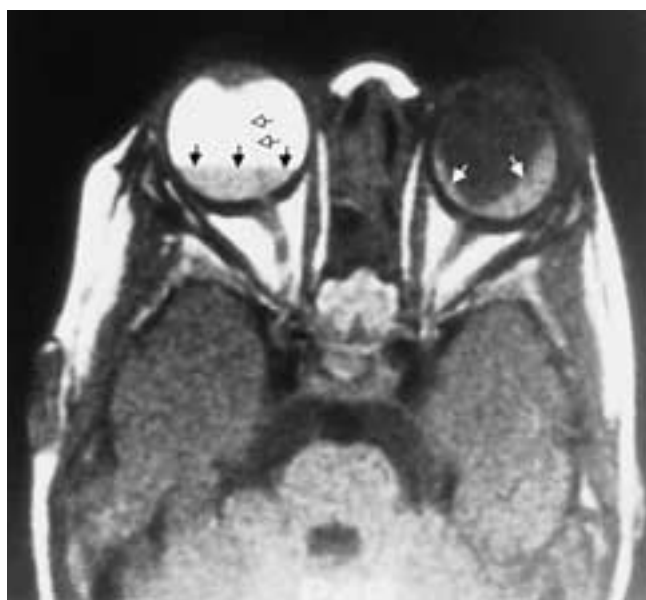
Posterior hyaloid and retinal detachment. Axial T1-weighted MR image shows the fluid-fluid level (*black arrows*) in the right vitreous chamber. This is thought to be caused by chronic (hyperintense) and acute (hypointense) hemorrhage in the subhyaloid or subretinal space. Note the detached leaves of the retina of the left eye (*white arrows*). The patient was diagnosed as having Warburg's syndrome. (From Mafee MF et al. Persistent hyperplastic primary vitreous [PHPV]: role of CT and MRI. *Radiol Clin North Am* 1987;25:683–692.)
